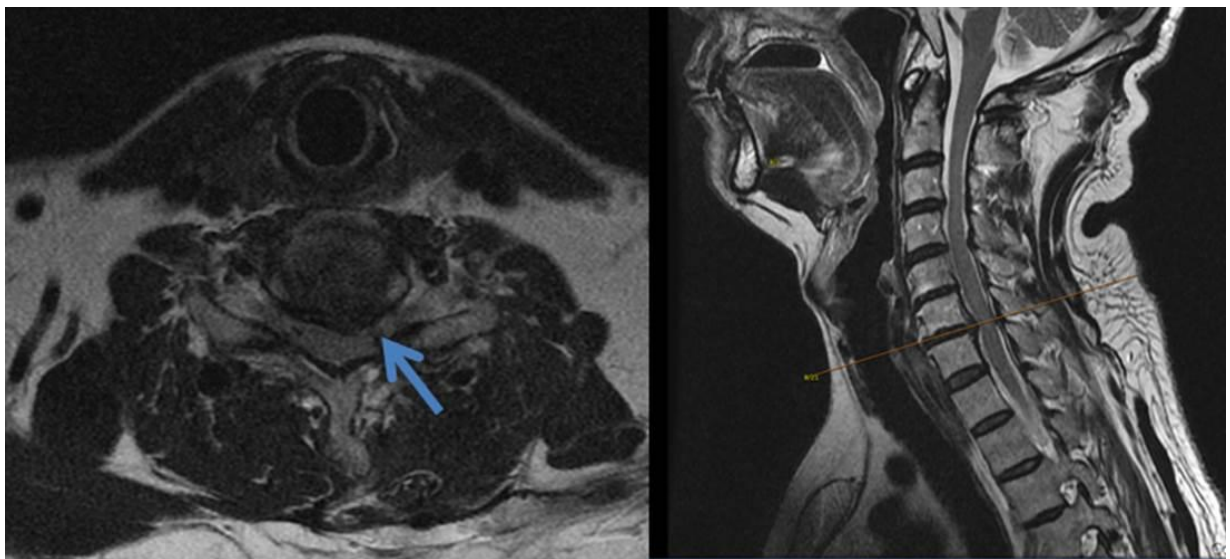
Cervical spine MRI revealed left anterior spinal cord compression at C6-7 levels. (a) T2 high-resolution axial weighted image at C7 level (b) T2 high-resolution sagittal weighted image at C7 level
